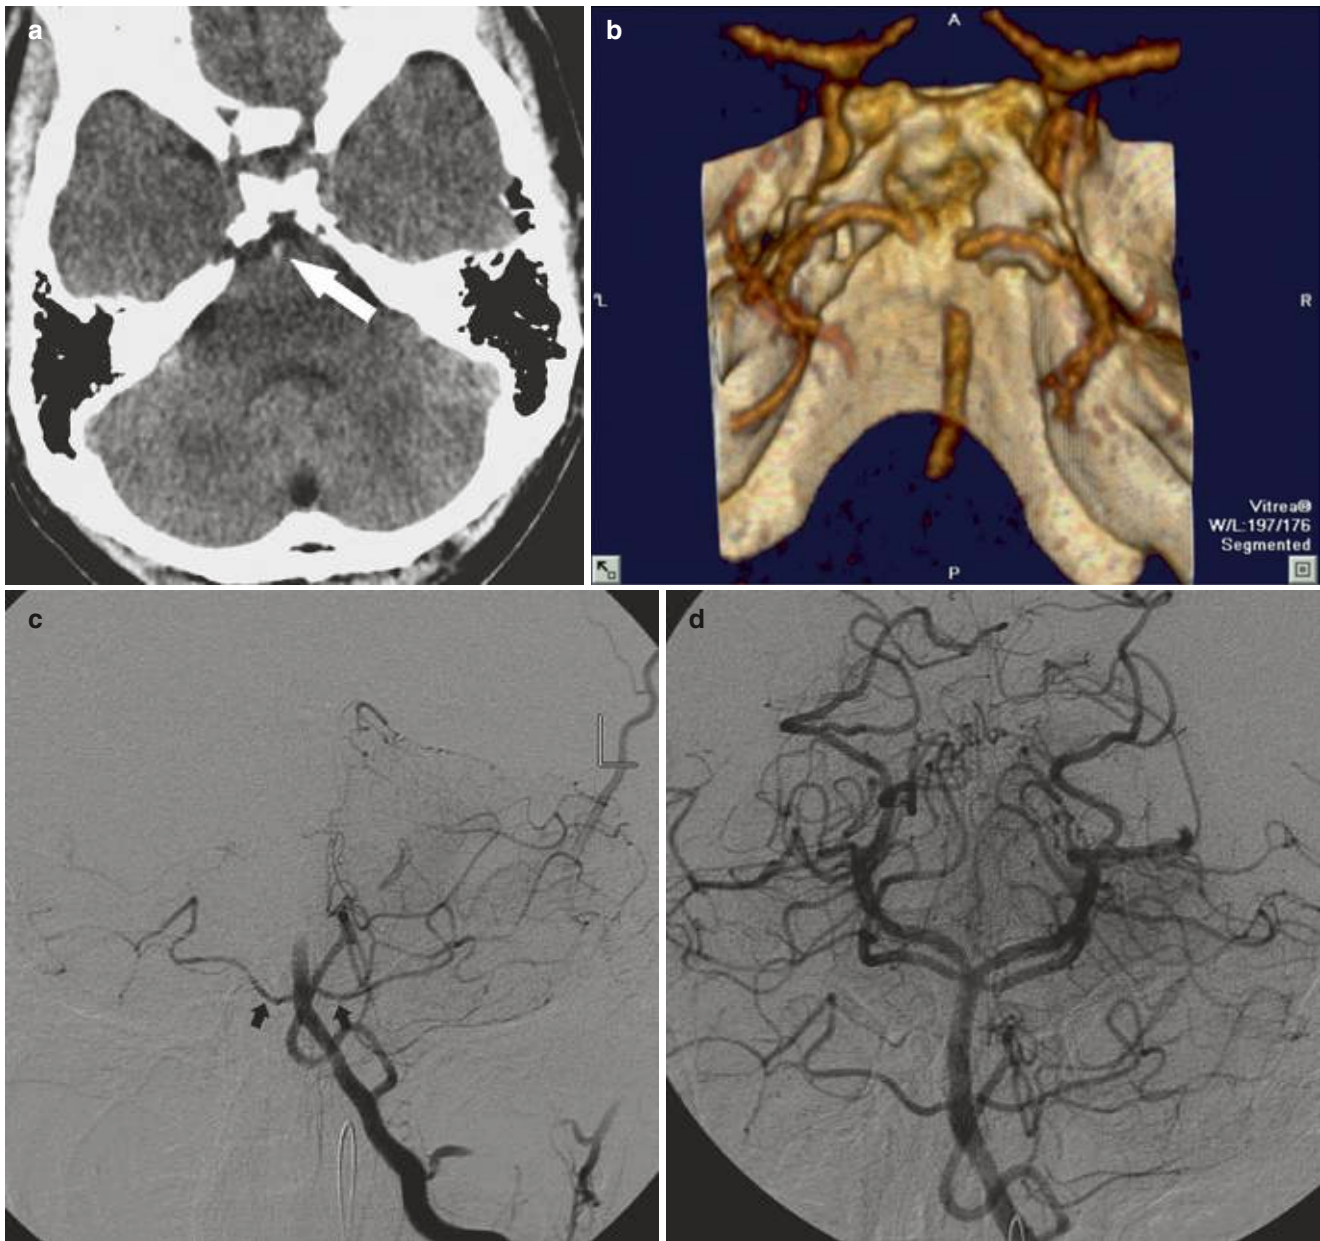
Thrombosis of the basilar artery. A 36-year-old man with acute vigilance deficit and horizontal nystagmus. (a) Native axial CT. The hyperdensity (arrow) is due to the thrombus in the basilar artery (*positive vessel sign*). (b) 3D-CTA (pa view) demonstrating the closed distal part of the basilar artery. (c) DSA of the left vertebral
